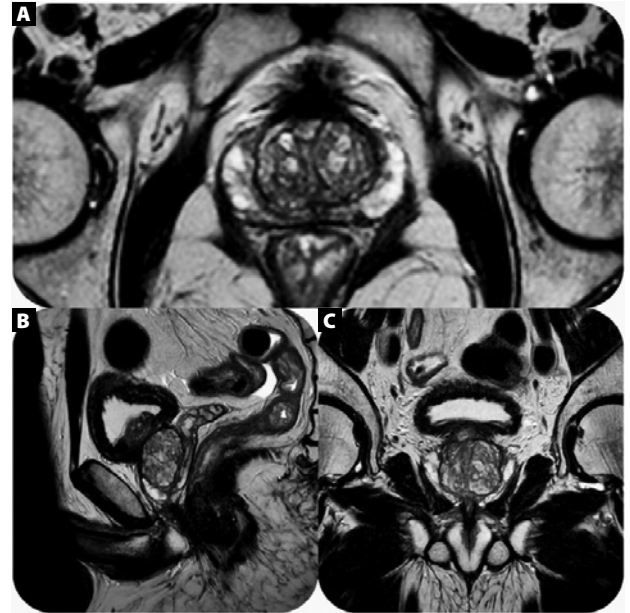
T2-weighted axial (A), sagittal (B), and coronal (C) MR images of the prostate using the torso coil. Images courtesy of the author.
